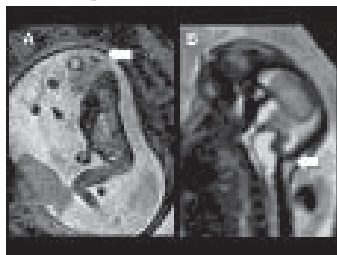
A&B, 2A: Anencephaly seen on MRI as a midline sagittal section with absence of bony calvarium and the brain parenchyma exposed to the CSF. The eyeball appears relatively large. Figure 2 B shows Iniencephaly featured by a midline split of medulla and cervical cord into equal halves.
